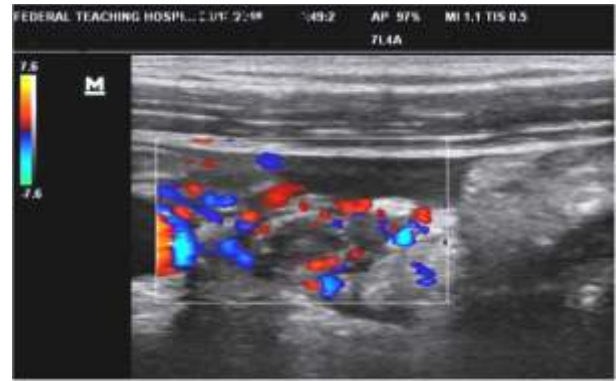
Transverse duplex sonographic image of an inflamed appendix which shows increased flow within and around the appendix.
